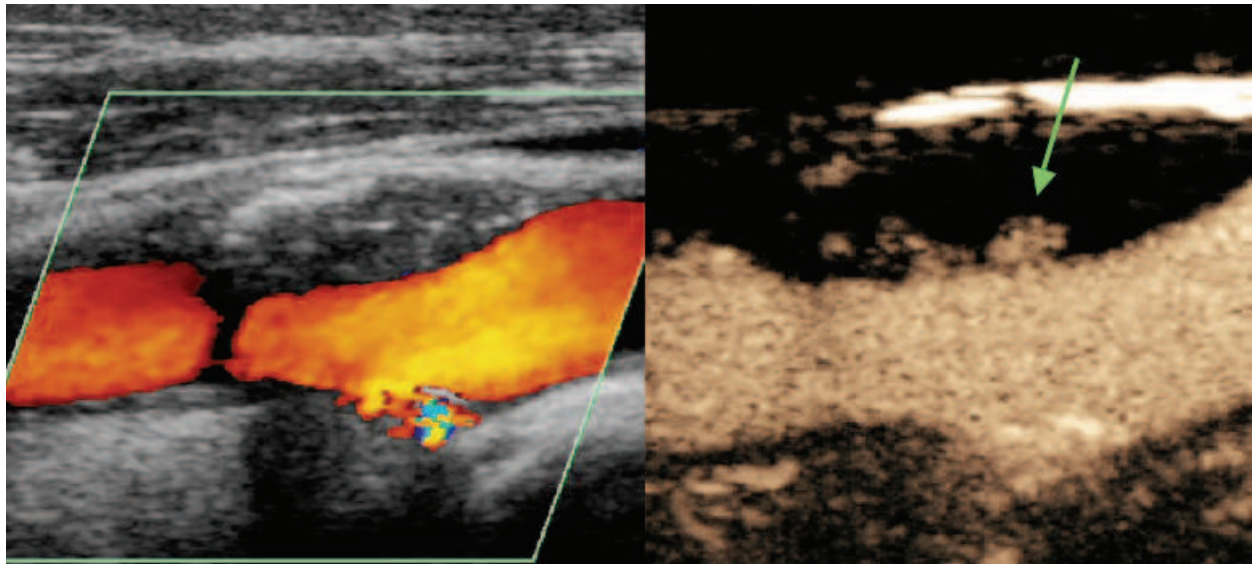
Contrast carotid ultrasound of a ulcerated plaque. Ultrasound contrast agents better identify plaque surface and ulceration (green arrow).
